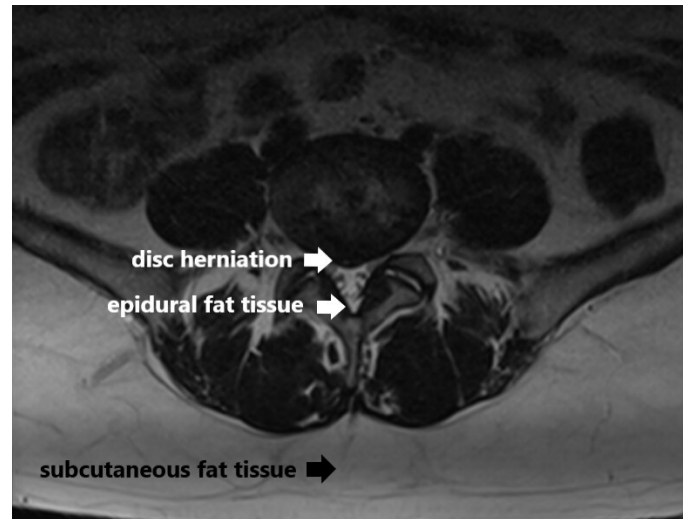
In axial T2-weighted lumbar MR images; disc herniation, epidural fat tissue, and subcutaneous fat tissue are shown with arrows.
